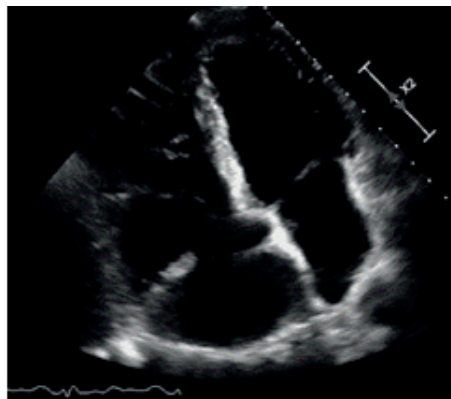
Echocardiogram in 2010. Fractional area change (FAC): 23%. Tri-cuspid annular plane excursion (TAPSE): 13 mm. Systolic pulmonary artery pressure: 90 mmHg. Right ventricular end-diastolic area (RVEDA): 28 cmq.
